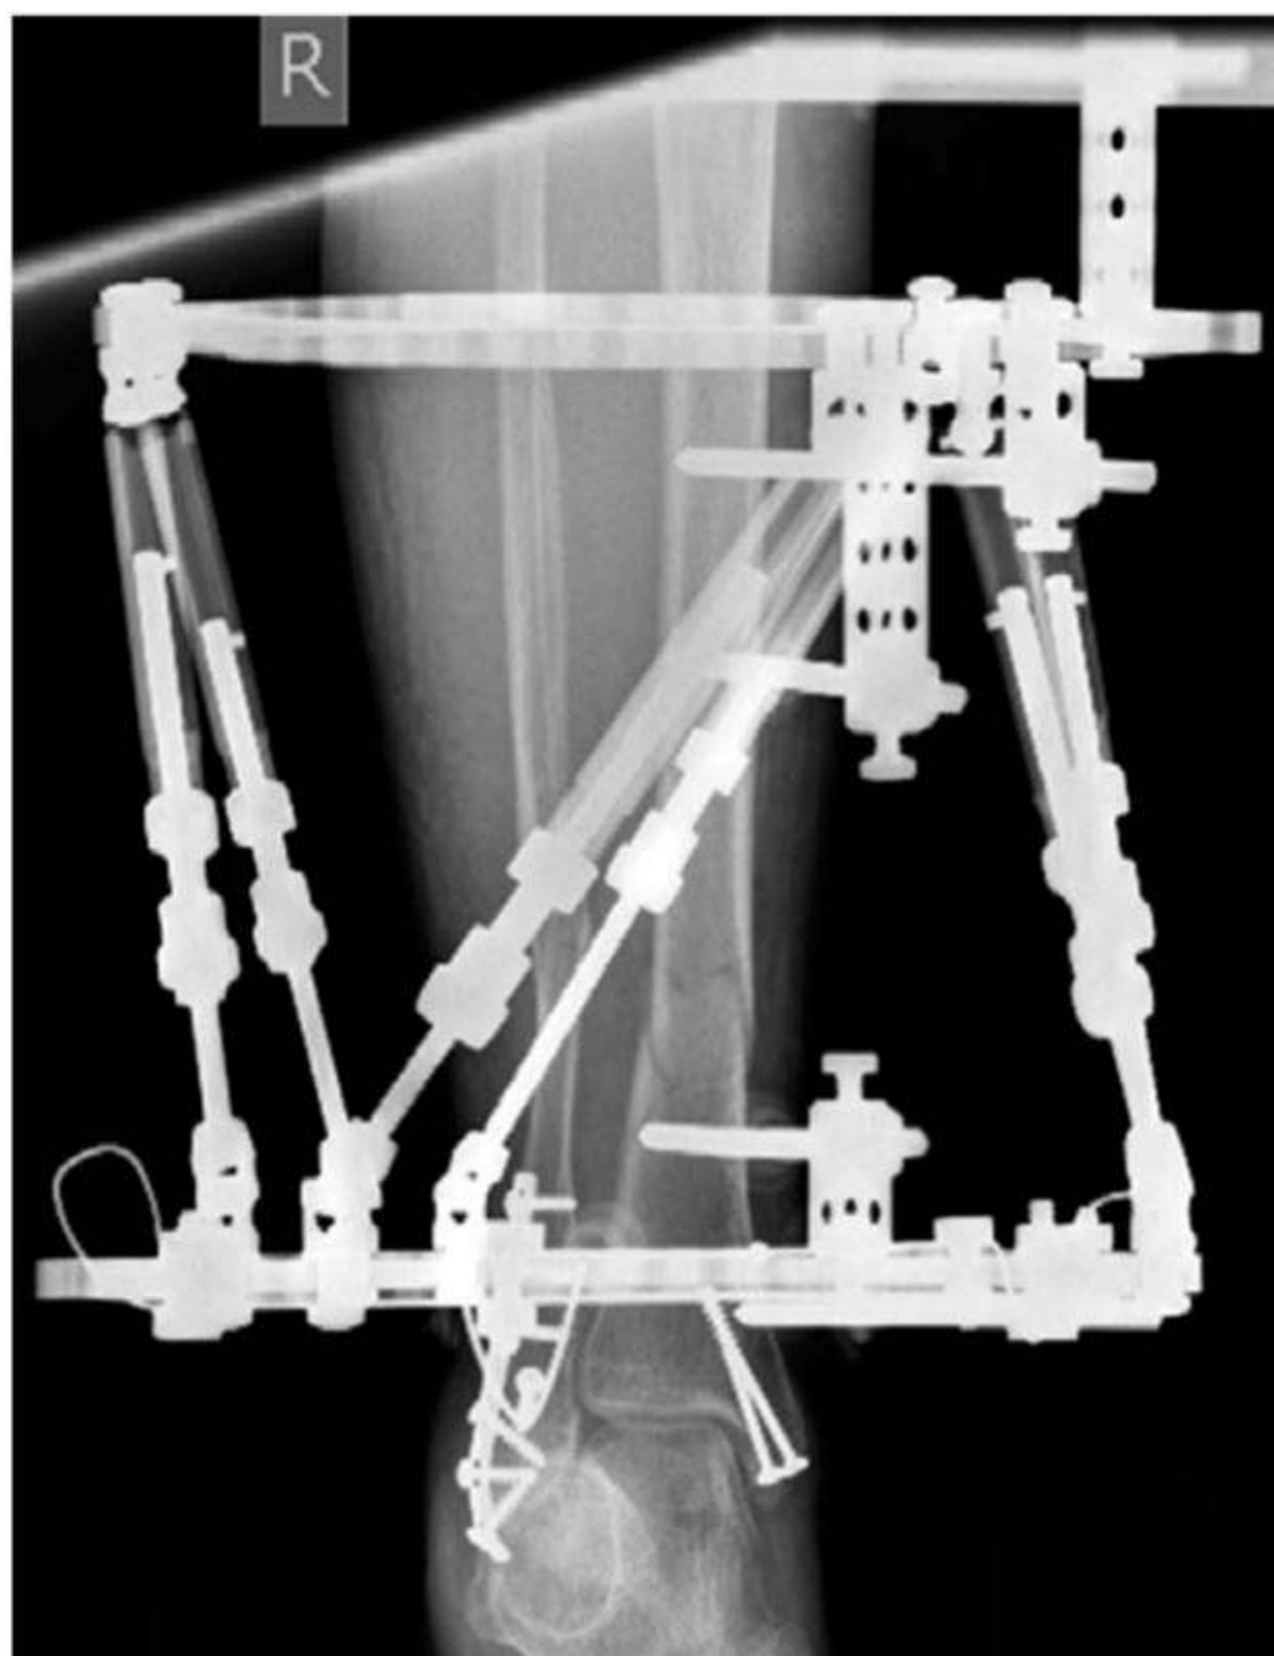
Anteroposterior (AP) radiograph right distal tibia with circular frame *in situ*.
